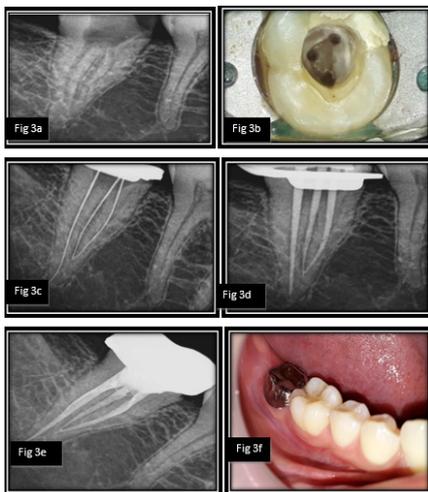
preoperative radiograph, Fig 3b-access cavity preparation showing melton's classification III, Fig 3c-working length determination, Fig 3d-Master cone selection, Fig 3e- obturation, Fig 3f- Crown placement
